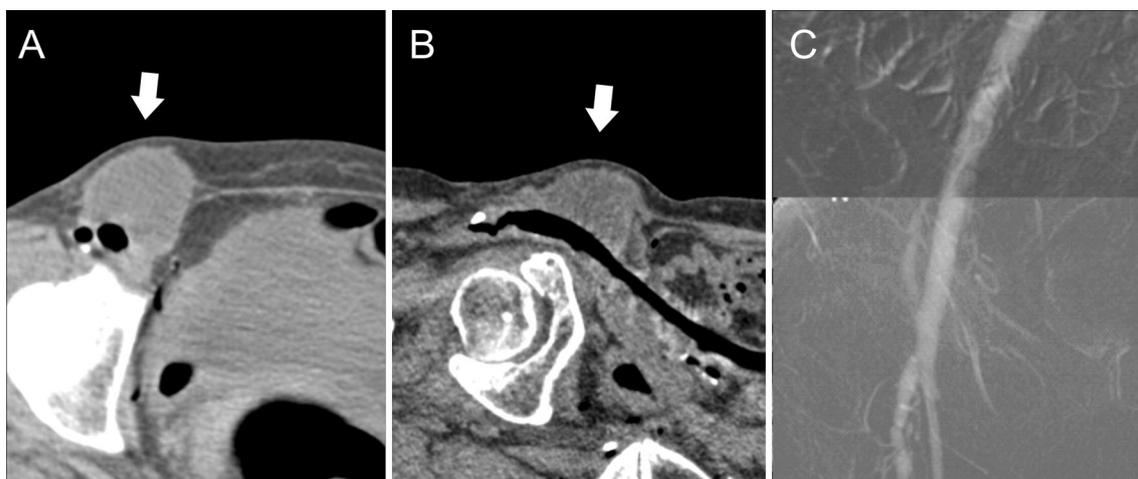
Lymphocele in CO₂-CTA (A axial, B sagittal) and DSA (C) of the femoral artery in a patient with a bifemoral aortic stent graft. Whereas the finding is clearly visible in CO₂-CTA, DSA does not permit the assessment of the pathology
